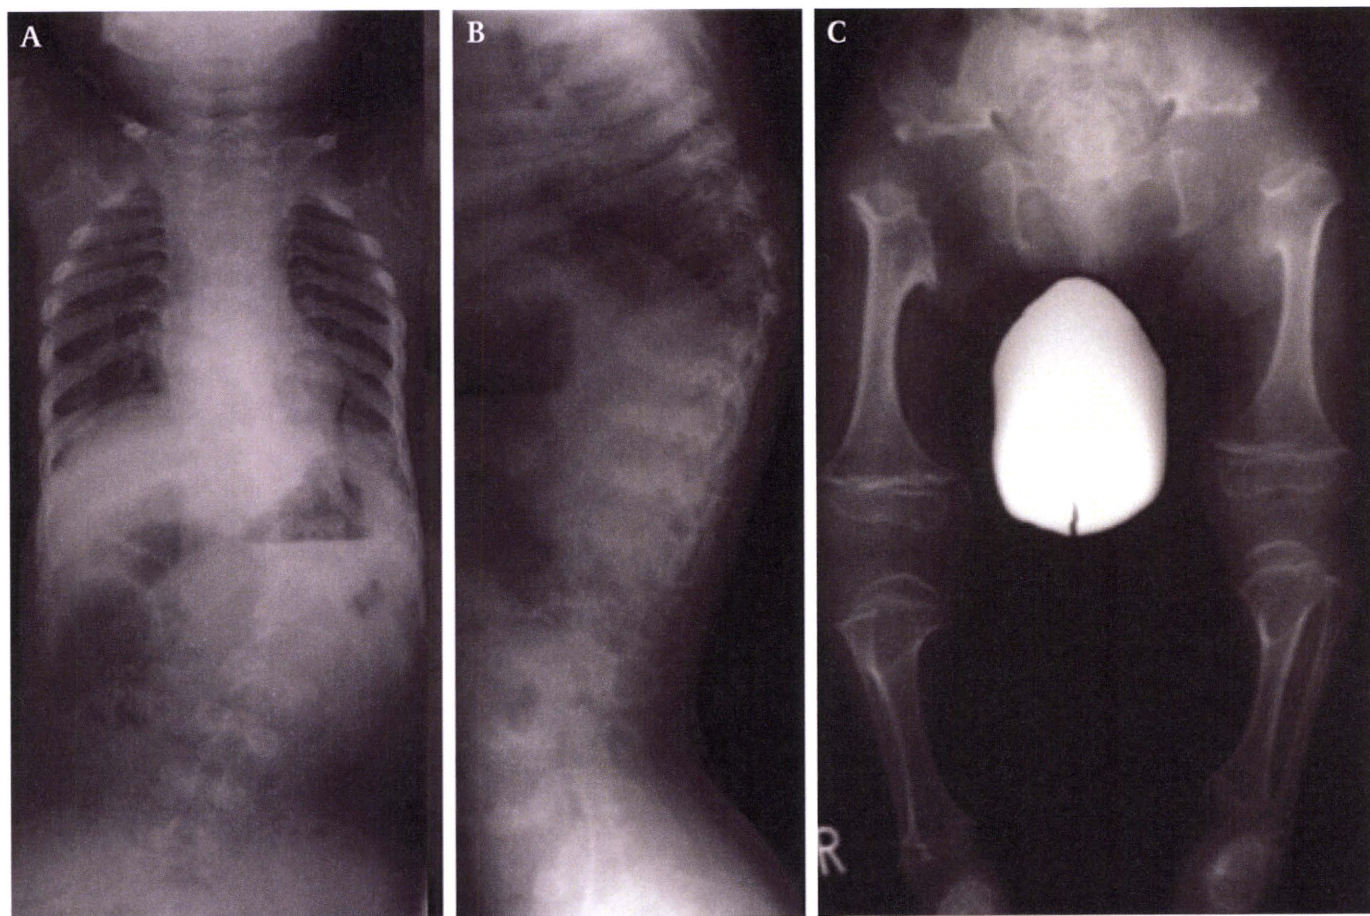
Radiographs of metatropic dysplasia (M8). (A) AP (antero-posterior) view of trunk, (B) lateral view of the thoracolumbar spine and (C) AP view of the lower extremities at age 3 years. There are thoracolumbar kyphoscoliosis, severe platyspondyly with overfaced pedicles and flared ilia with supra-acetabular notches. Significantly flared metaphyses of the long bones present a dumbbell deformity. Epiphysial ossification of the proximal femora is significantly retarded.
